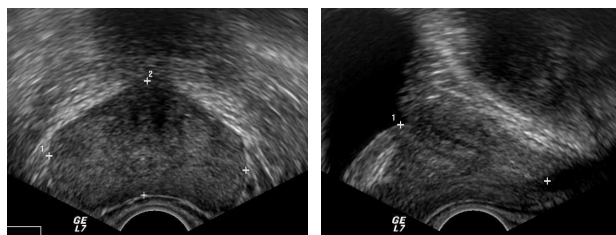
Prostate volume measurement using transrectal ultrasonography by 3 distance ellipsoid volume measurement method.
